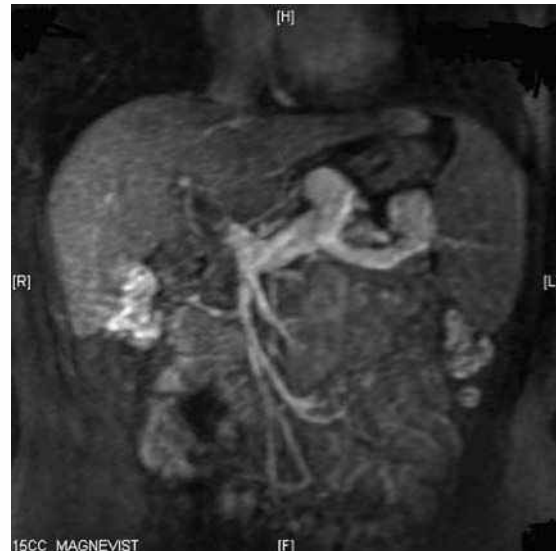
Contrast-enhanced MR image shows Yerdel's Grade II PVT.
